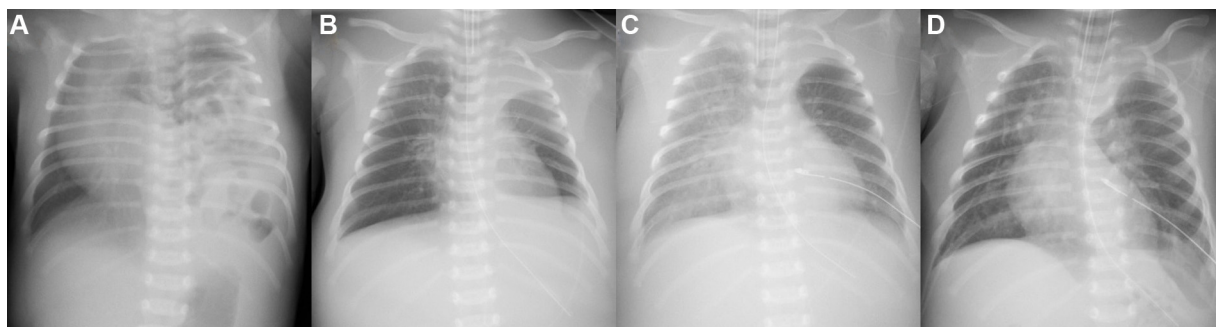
Chest radiography. (A) Day 0: Left diaphragmatic hernia with all of the small intestine and the right half of the colon prolapsing into the left pleural cavity, displacing the left lung cranially. (B) Day 2: Both lungs were still hyperlucent after the repair of congenital diaphragmatic hernia and balloon atrial septostomy, and the left lung appeared immature. (C) Day 11: An unaffected right lung became congested. A chest tube was placed in the left thoracic cavity. (D) Day 22: Right lung congestion improved following mechanical hypoventilation, and left lung volume increased.
